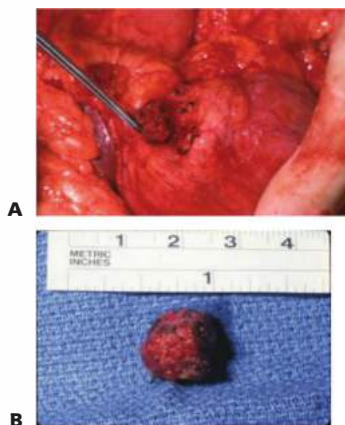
• A. Enucleation of an insulinoma from the deep tissue of the head of the pancreas. Once the capsule of the insulinoma is seen, intraoperative ultrasound is no longer needed to guide the dissection. B. Intact pancreatic head insulinoma after enucleation. Small amounts of pancreatic parenchyma are attached to the lesion.
